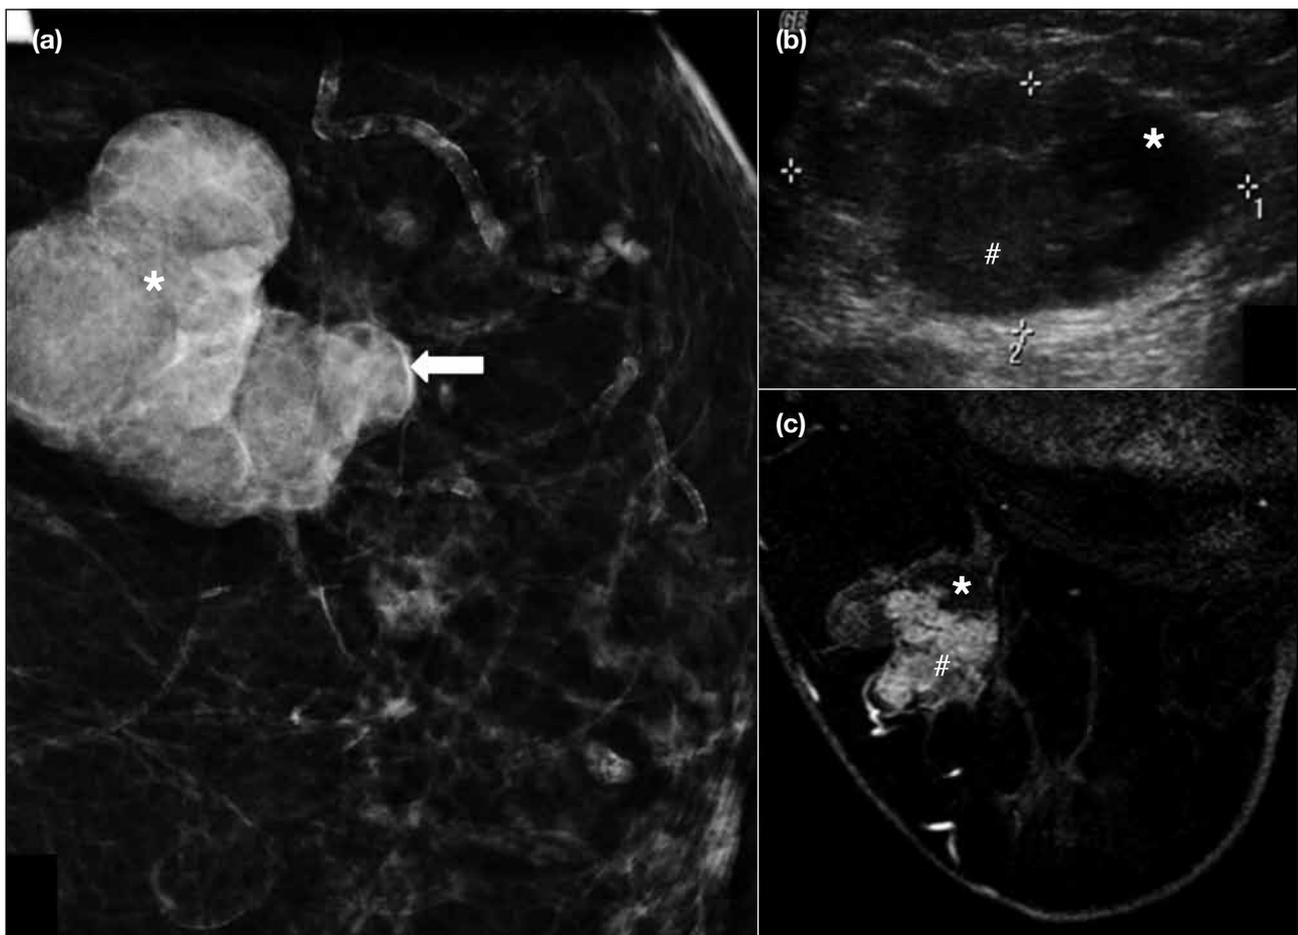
(a) Compression mammogram of the left breast of a 47-year-old woman showing an oval hyperdense (*) nodule with microlobulated margins (arrow), located at the junction of the lateral quadrants. (b) Ultrasound image showing a solid-cystic complex mass (*) with the solid (#) component at the left portion of the image, irregular morphology, circumscribed margins, and longest axis parallel to the skin, located at the junction of the lateral quadrants of the breast (calipers). (c) T1-weighted magnetic resonance image after intravenous contrast injection showing oval complex mass with circumscribed margins and cystic (*) and solid (#) components.
